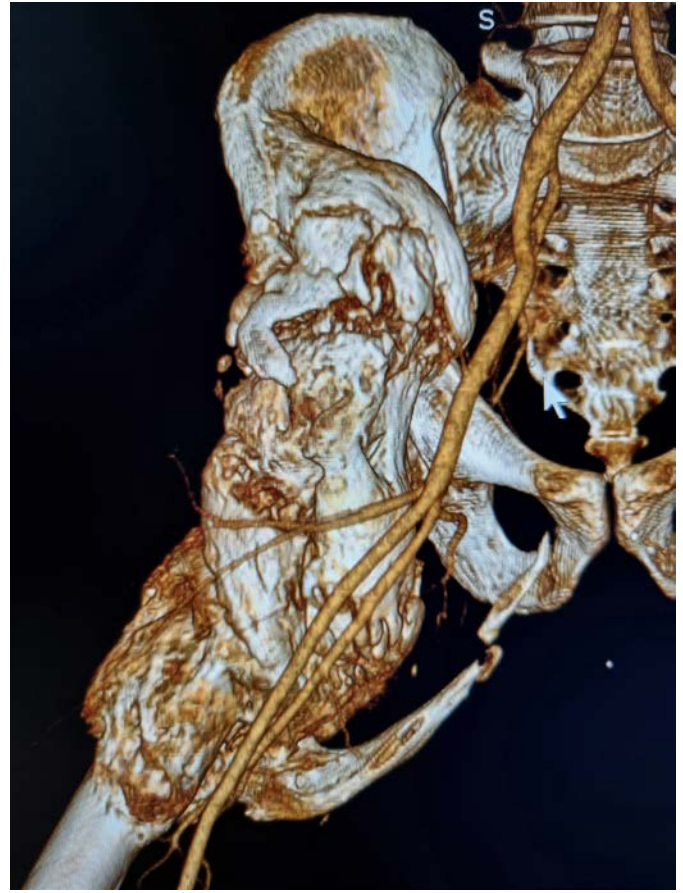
3D CT reconstruction of the extensive HO of the right hip. The articulation was not involved.
